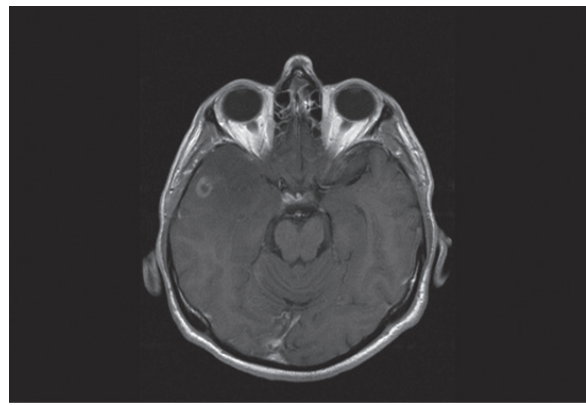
MRI before surgery. Axial T1-weighted image: tumor in the right temporal lobe mostly marginally after administering contrast
